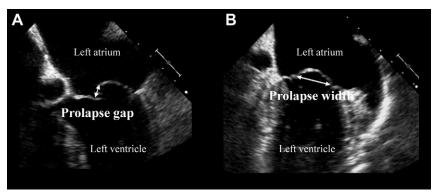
An example of a 2D transesophageal echocardiographic image for the assessment of MV prolapse.
